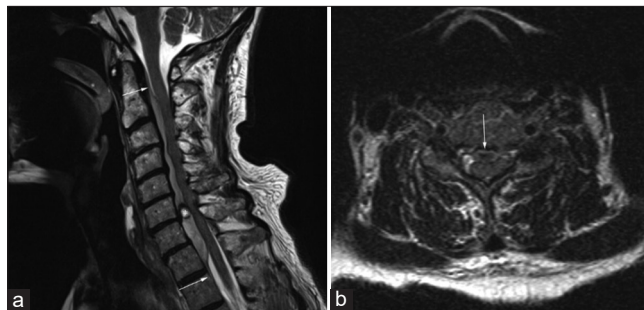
Cervical spine MRI (a) T2-weighted sagittal view demonstrating extensive ventral epidural hematoma extending from the mid-body of C2 to the superior edge of T2. *Indicates focal area of possible active hemorrhage measuring 7 mm × 6 mm at the level of the C6-7 disc space. (b) T2-weighted axial view with arrow indicating severe spinal cord impingement corresponding with focal area of hemorrhage. Arrows in the figure represent the extent of the epidural hematoma from the mid-C2 vertebral body to T2.
